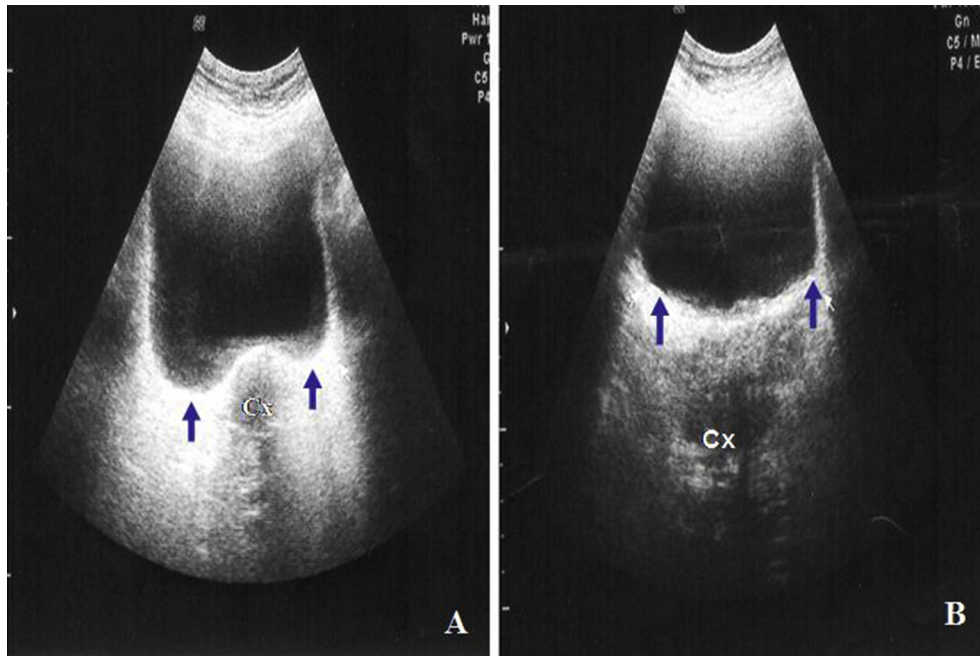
The sonographic pictures of paravaginal defects (A) Blue arrow showed the paravaginal defects prior to and after operation (B) Blue arrow showed there is no paravaginal defects prior to and after operation. Cx: cervix of uterus.
